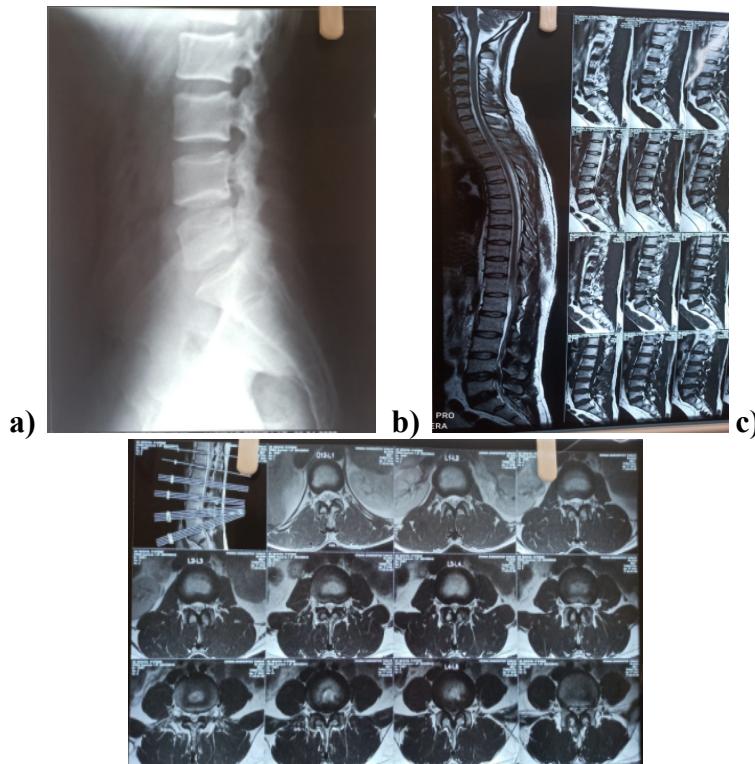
a) preoperative x-ray, b) preoperative MRI – sagittal section, c) preoperative MRI – axial section
